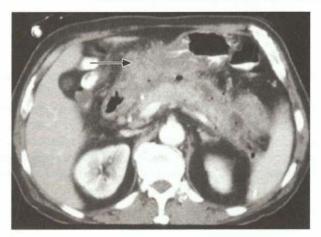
Contrast enhanced CT (CECT) scan is the gold standard investigation in cases of acute pancreatitis. Useful after 7 days of acute pancreatitis. This photograph shows extensive necrosis. CT scan also helps in detecting pseudocysts, abscesses, presence of gall stones or any other unsuspected pathology in the abdomen. Modern thinking is to wait for 4–6 weeks for separation of necrosis before surgical necrosectomy
